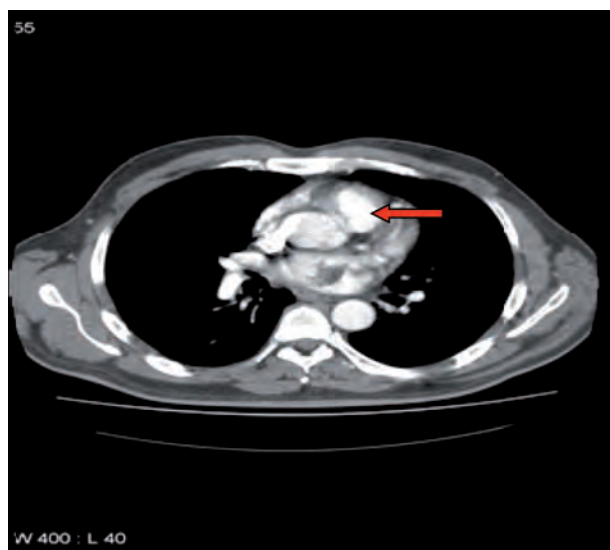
Image of angio-CT of the myxoma in the left auriculum.
